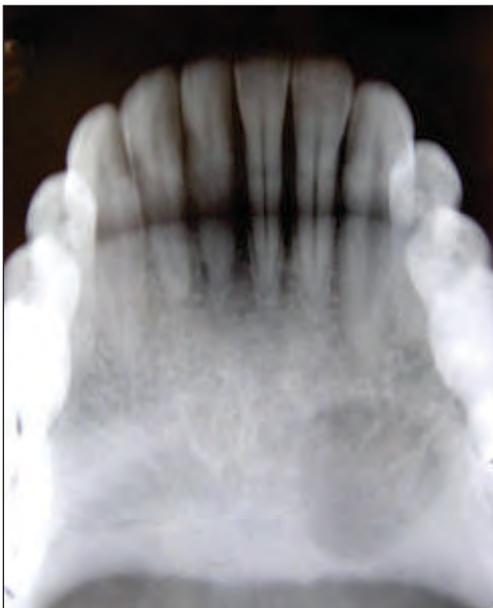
Anterior occlusal radiograph showing cone shaped radiolucency not associated with the roots of the teeth.
